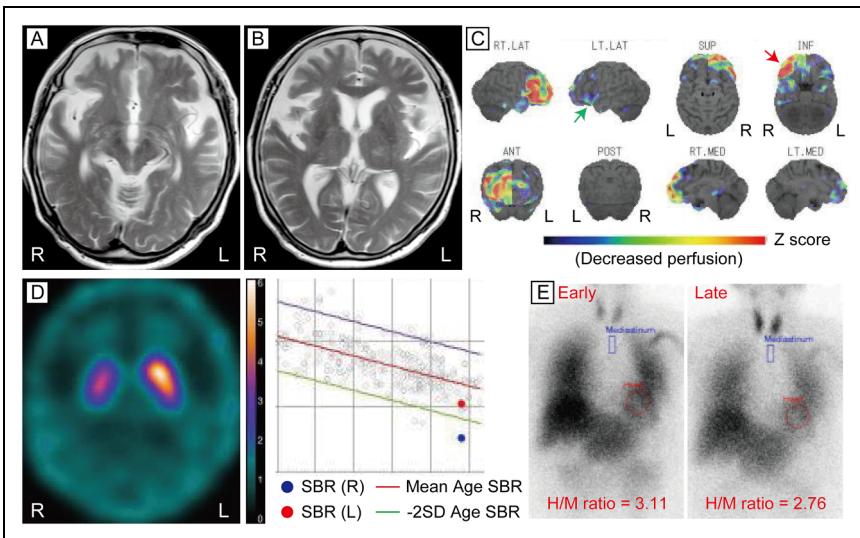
(A and B) Magnetic resonance imaging (MRI) T2 weighted images of the frontal lobe showing severe frontal lobe atrophy, which was more evident in the right lobe. (C) ^{123}I -IMP SPECT and three dimensional-stereotactic surface projection (3DSSP) analysis showing a decrease in cerebral blood flow (CBF) in the vast majority of the right frontal area, including the superior frontal gyrus (red arrow), in certain lesions of right temporal lobe, and in the left opercular inferior frontal gyrus (green arrow). (D) Dopamine transporter (DAT) SPECT imaging using ^{123}I -ioflupane showing a significantly lower right specific binding ratio (SBR), but (E) normal iodine- ^{131}I -labeled metaiodobenzylguanidine (^{131}I -MIBG) scintigraphy results.
